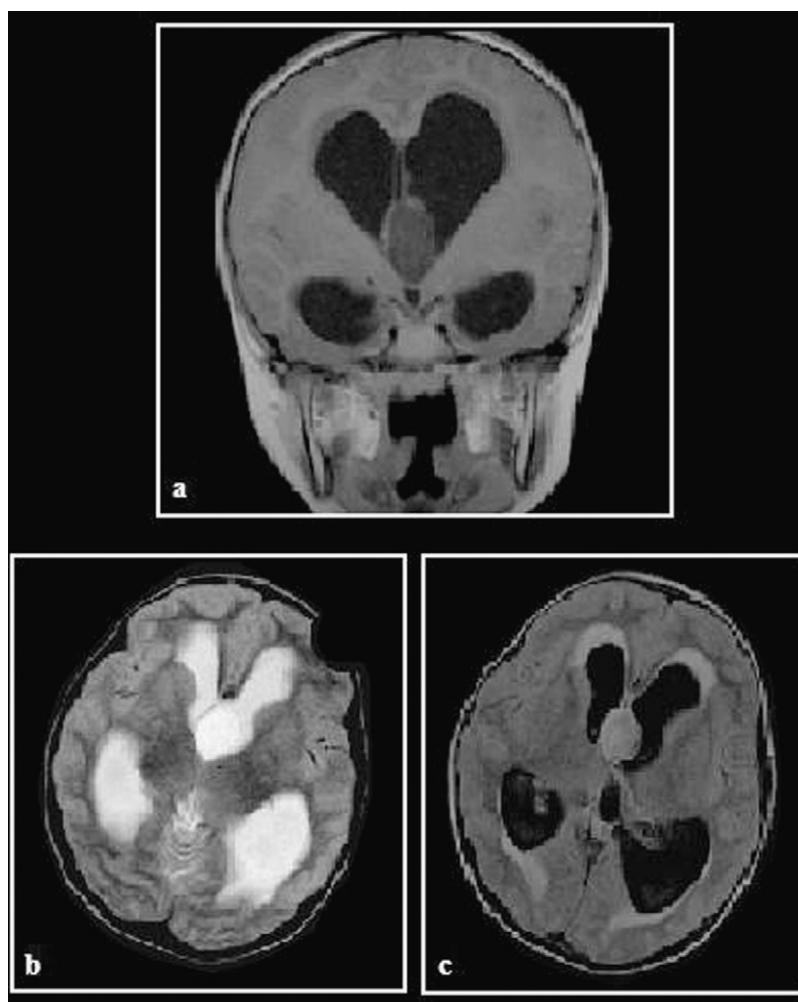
MRI of the brain (a) T1-weighted in coronal view, (b) T2-weighted in axial view and (c) FLAIR in axial view. There is a well defined, oval mass anterior to the third ventricle. It is homogenously isointense on T1-weighted and hyperintense on T2-weighted as well as FLAIR sequences. There is associated acute supratentorial obstructive hydrocephalus.
